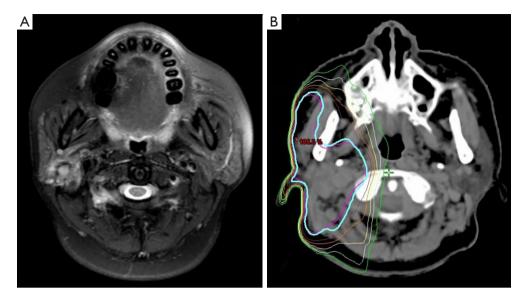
A typical case of right parotid gland tumor (A) axial T2-weighted MRI (B) isodose line of treatment plans of IMRT. MRI, magnetic resonance imaging; IMRT, intensity modulated radiotherapy.
